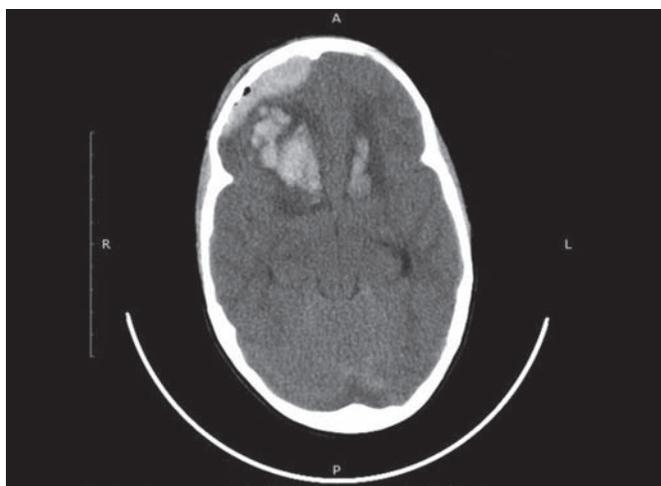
Noncontrast CT axial image showing large acute SDH in right frontal region and intraparenchymal hematoma with surrounding edema in bilateral frontal lobe
